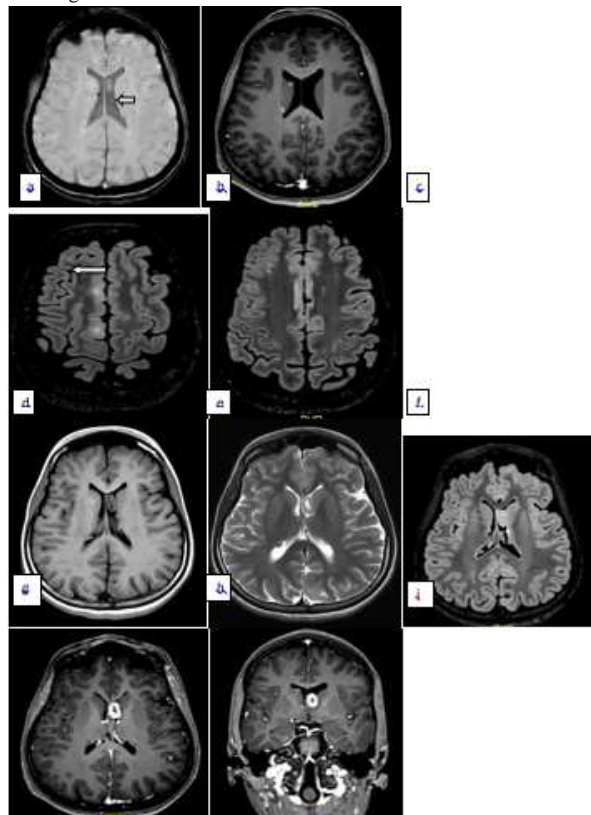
Axial SWI images of MRI brain plain (a) showing multiple small well defined bilateral calcified subependymal nodules, few of them showing enhancement (b) on post contrast images.
